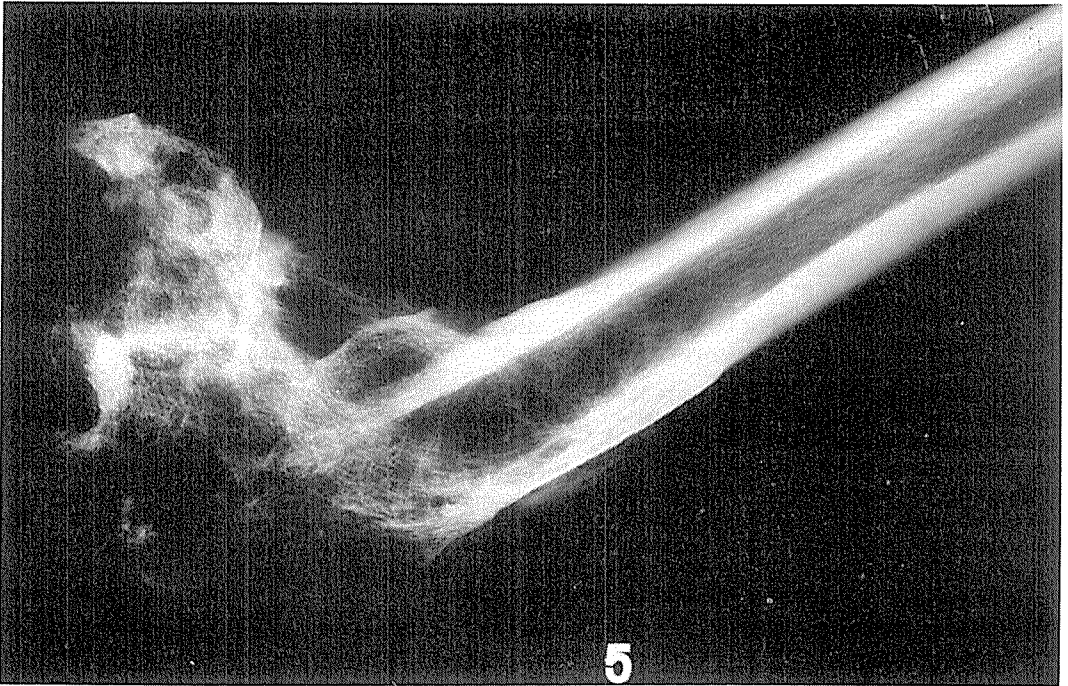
No. 5. X-Ray of proximal femur.
